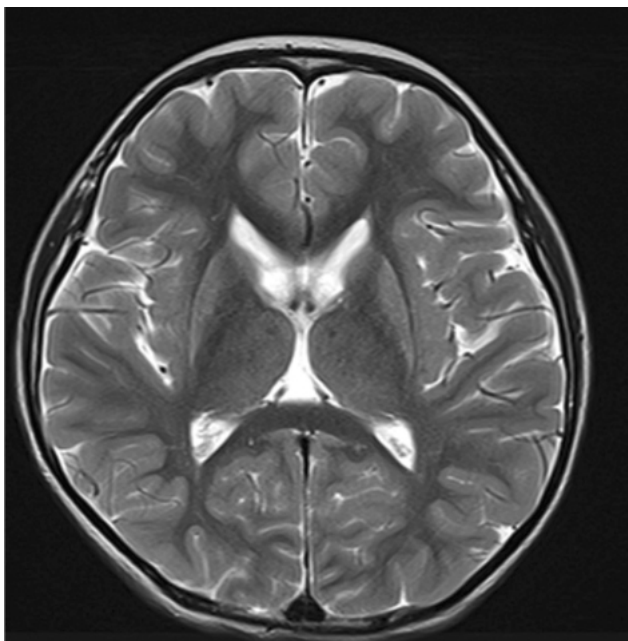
MRI Brain (with contrast) on Day 1. *MRI brain showed no focal lesion.
